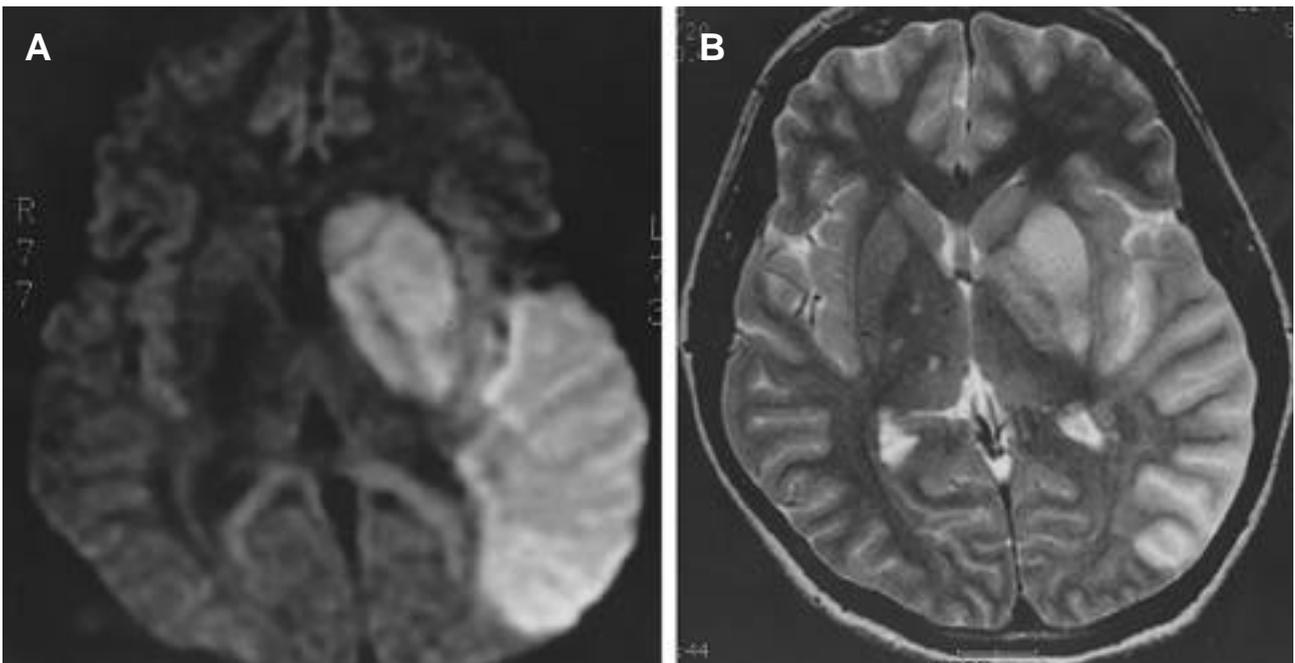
T2 magnetic resonance image (A) and diffusion weighted image (B) of the brain showed an increased signal in the left middle cerebral artery territory, which is consistent with an infarction.
